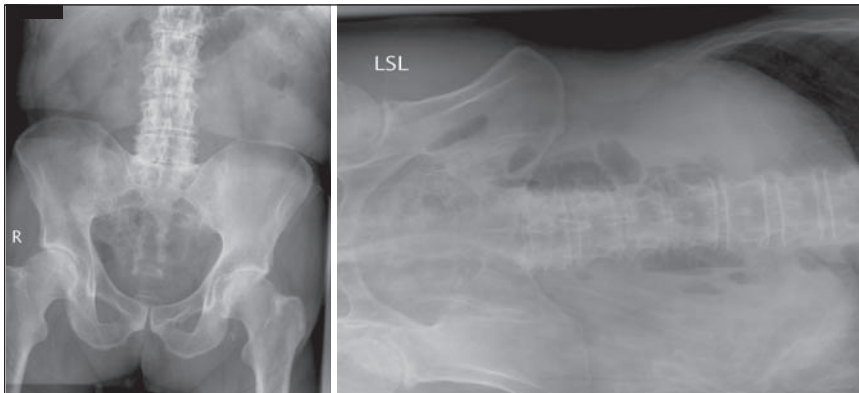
Plain supine (left) and left lateral (right) abdominal radiographs.
